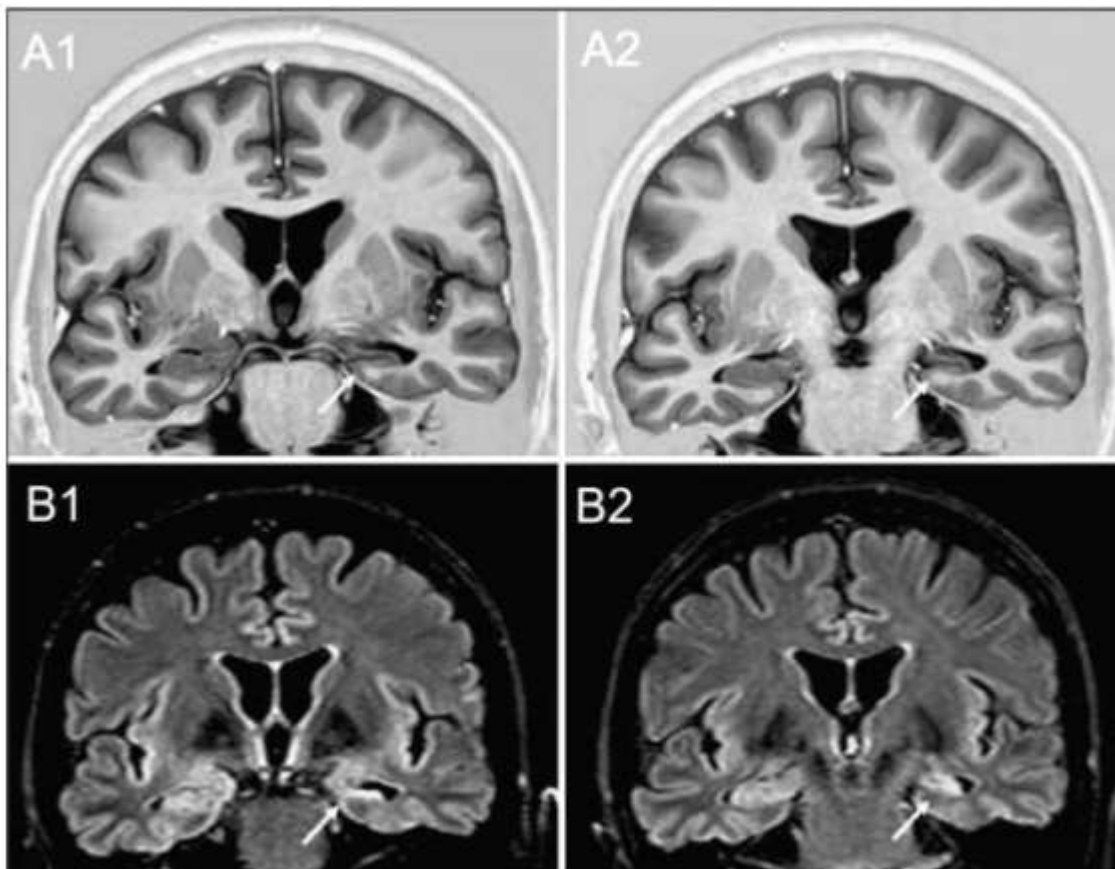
MRI brain coronal T1-weighted inversion recovery (A1 and A2) and T2 fluid-attenuated inversion recovery (FLAIR) images (B1 and B2) from a patient with left mesial temporal lobe epilepsy (TLE) showing signs of left hippocampal sclerosis (arrows): hippocampal atrophy with abnormal shape and hyper intense signal on T2-FLAIR images (15).
